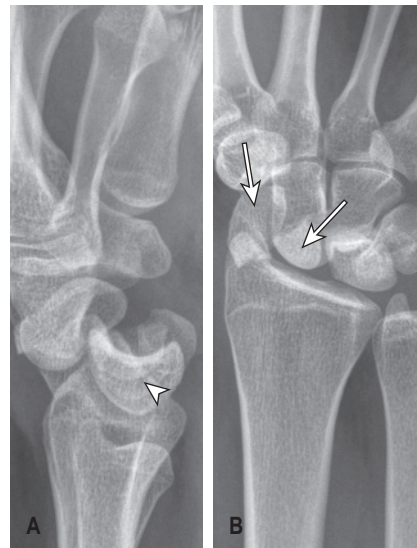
Lateral (A) and frontal (B) radiographs of the wrist demonstrate a fracture of the scaphoid (*arrows on fragments*) and transcaphoid perilunate dislocation. Note that the lunate remains congruent with the radius and ulna (*arrowhead*), differentiating this injury from a lunate dislocation.
